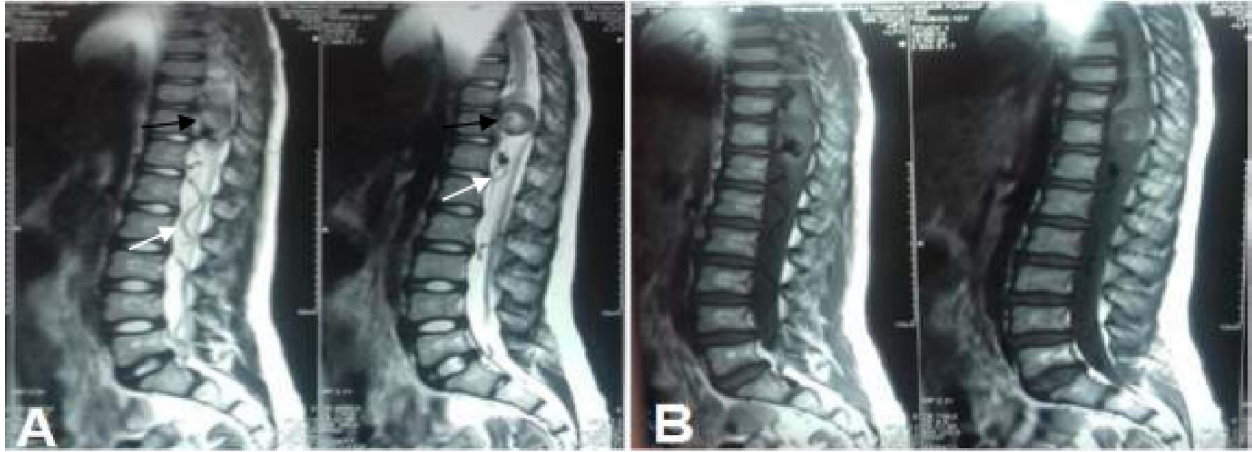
MRI dorsolumbar spine of case (11)
